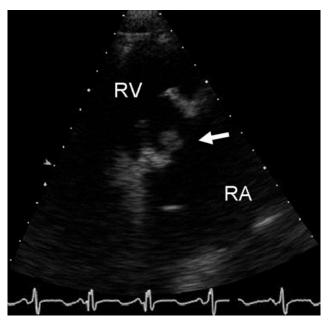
Transthoracic echocardiogram showing a bioprosthetic tricuspid valve with a 1.0 cm \times 1.5 cm vegetation (arrow). RA = right atrium. RV = right ventricle.
